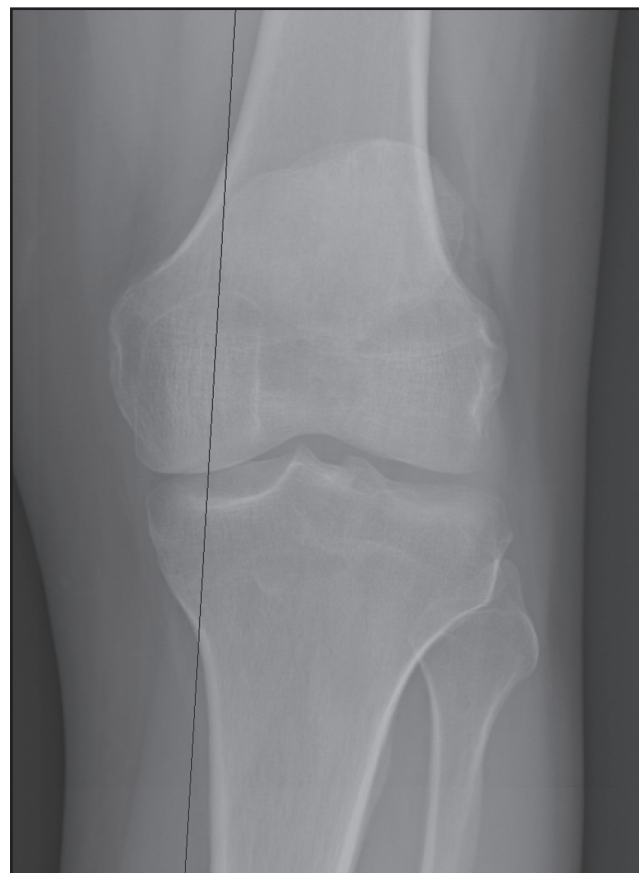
Anteroposterior radiograph for planning of a corrective osteotomy (cropped image from a long-leg alignment film). The weight-bearing axis lies in the medial compartment in this varus aligned knee.
